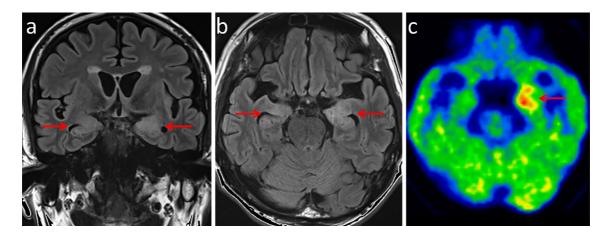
a, b: MRI (T2-weighted FLAIR images) of the head revealed a high intensity signal in the bilateral limbic system. c: PET/CT of the brain showed increased FDG avidity in the left mesial temporal region (SUVmax, 13.2). CT: computed tomography, FDG: ¹⁸F-fluorodeoxyglucose, FLAIR: fluid-attenuated inversion recovery, MRI: magnetic resonance imaging, PET: positron emission tomography
